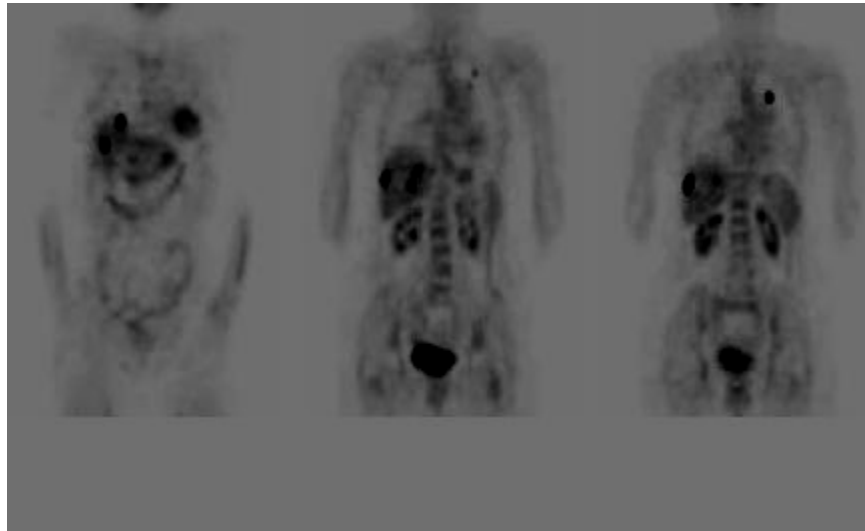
A case of metastatic liver lesion and PET/FDG revealed primary site in the lung.
